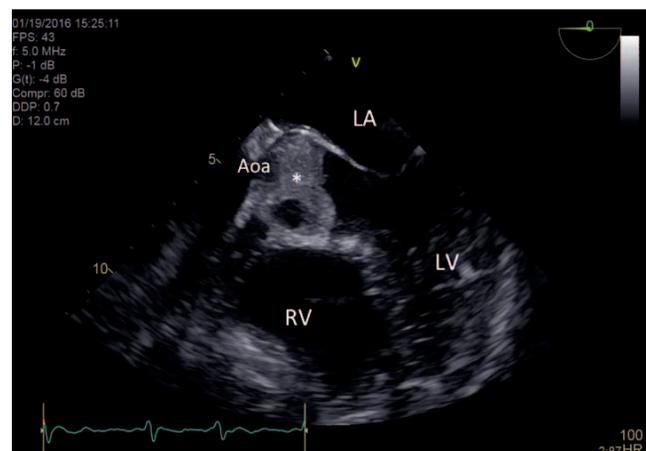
Transesophageal echocardiogram midesophageal 5-chamber view. The thrombus is identified by an asterisk. Aoa, ascending aorta; LA, left atrium, LV, left ventricle; RV, right ventricle.
